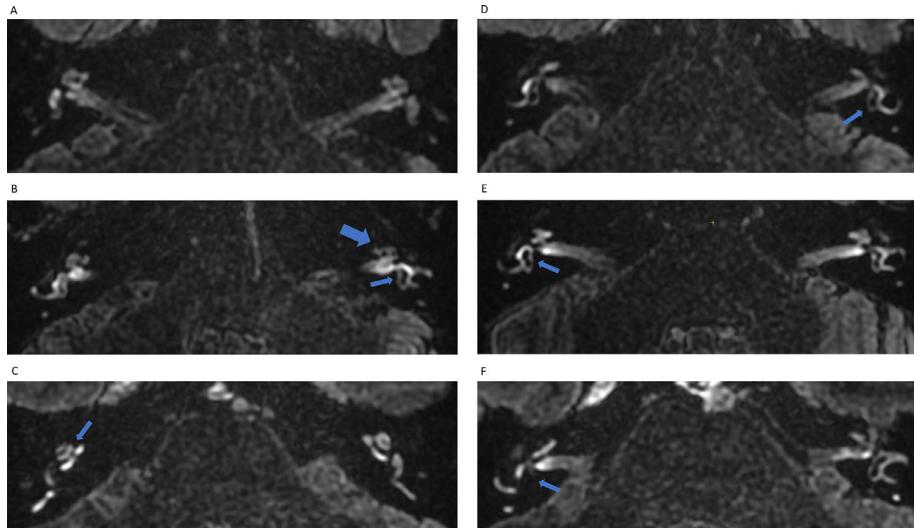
Magnetic resonance imaging (MRI) example scans of patients with clinically defined Ménière's disease (MD). Affected ears are marked with arrows. (A) An example case of the normal cochlea where scala vestibuli is evenly enhanced - a 37-year-old male with right-sided MD for the last 13 years, the hearing level within a normal range (PTA 20 dB HL), and SP/AP ratio 0.34; (B) An example case of cochlear hydrops grade I - partial obstruction of the scala vestibuli by mildly dilated cochlear duct (pointed by the big arrow); An example case of vestibular hydrops grade II using Bernaerts modification (Barath grade I) - dilatation and confluence of saccule and utricle with visible circular enhancing perilymphatic space of vestibule (pointed by the small arrow) - a 54-year-old male with MD in the left ear for the last three years with PTA level 35 dB HL, and SP/AP ratio 0.22; (C) An example case of cochlear hydrops grade II - distended cochlear duct entirely obliterating scala vestibuli (pointed by an arrow) - a 53-year-old male with MD on the right side for the last 21 years, PTA level 68.75 dB HL, and the SP/AP ratio 1.03; (D) An example case of normal vestibule without hydrops - non-enhancing saccule and utricle are easily visible, and the saccule is smaller than the utricle (pointed by an arrow) - a 37-year-old male with right-sided MD for the last 13 years, PTA 20 dB HL, and SP/AP ratio 0.34; (E) An example case of vestibular hydrops grade I using Bernaerts modification (Barath grade 0) - so-called extra low-grade vestibular hydrops, saccule is enlarged but still separated from the utricle (pointed by an arrow) - a 60-year-old male with right-sided MD for the last year, PTA 32.5 dB HL, and SP/AP ratio 0.73; (F) An example case of vestibular hydrops grade III using Bernaerts modification scale (Barath grade II) - in the vestibule, no perilymphatic space is visible due to saccule and utricle enlargement (pointed by an arrow) - a 58-year-old female with right-sided MD for the last five years, PTA level 67.55 dB HL, SP/AP ratio 0.47.
